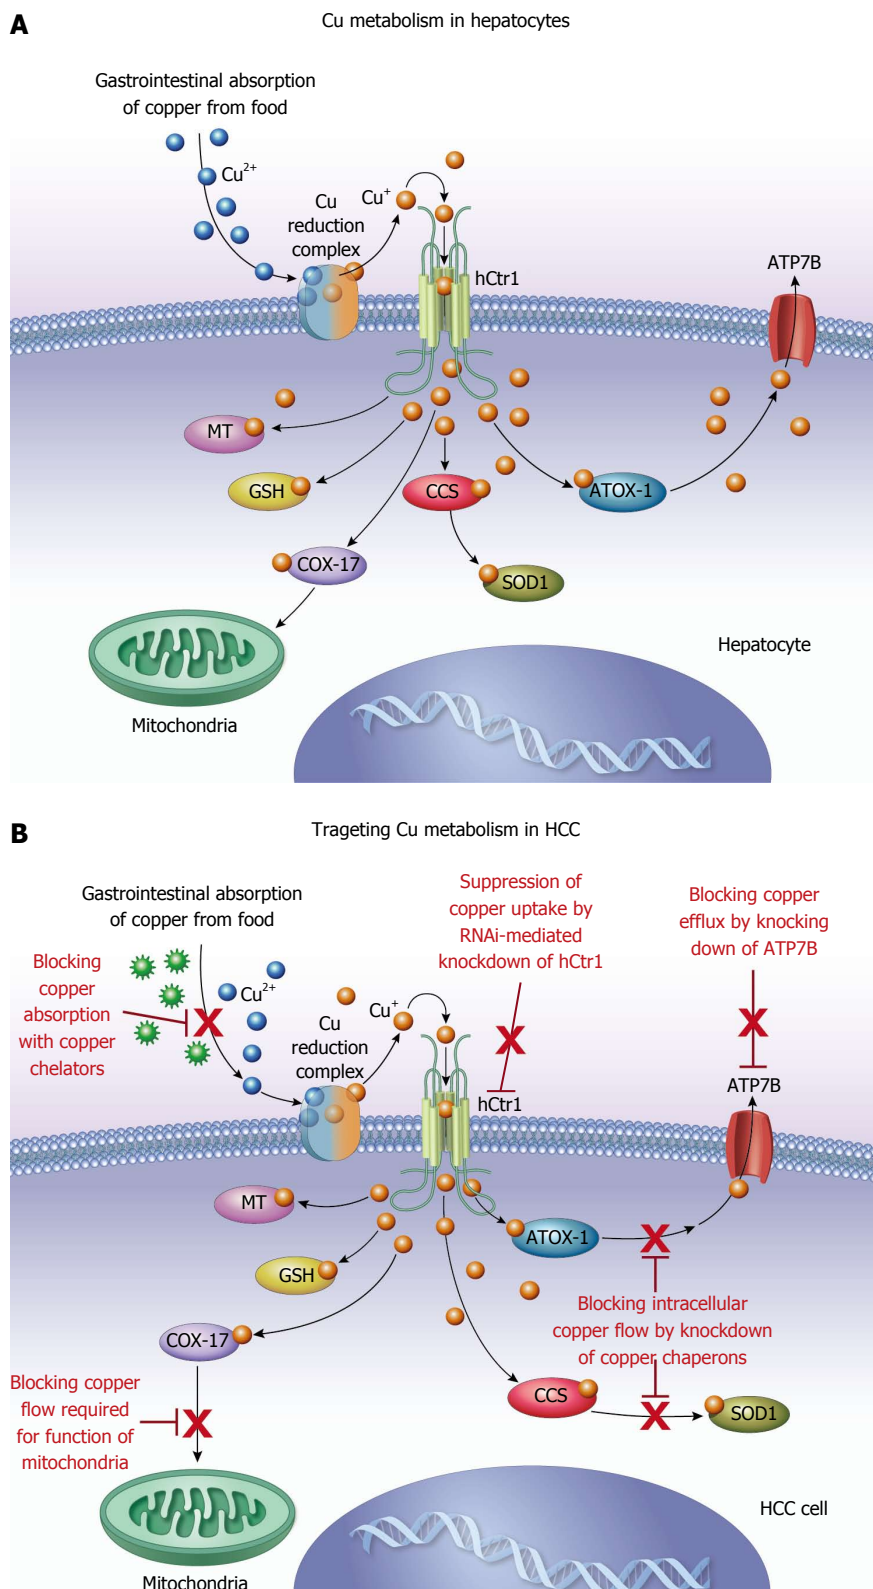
Perspective on targeting copper metabolism for the treatment of hepatocellular carcinoma. A: Copper metabolism in hepatocytes. Copper metabolism in hepatocytes is regulated by a network of copper transporters and chaperons. Following copper uptake mediated by the influx copper transporter, hCtr1, copper is transported intracellularly by copper chaperons and copper homeostasis is maintained by the outflow of copper mediated by the efflux copper transporter, ATP7B; B: Targeting copper metabolism for the treatment of hepatocellular carcinoma (HCC). Copper is required for cell proliferation and may play a role in the signaling transduction pathway regulating proliferation of HCC cells. Targeting copper metabolism with copper chelators has been tested for anti-copper therapy of HCC, with variable response. RNAi-mediated knockdown of hCtr1 and/or other copper chaperons is a potential new approach for targeted anti-copper gene therapy of HCC. Furthermore, ionic $^{64}\text{CuCl}_2$ or $^{67}\text{CuCl}_2$ have potential as new radiopharmaceuticals for systemic radionuclide therapy of HCC, based on increased ^{64}Cu uptake of HCC visualized on preclinical PET/CT images. hCtr1: Human copper transporter 1; ATOX-1: Antioxidant 1; Cox 17: Cytochrome c oxidase 17; CCS: Copper chaperone for superoxide dismutase; SOD1: Superoxide dismutase 1; GSH: Glutathione; MT: Metallothionein; ATP7A: Copper-transporting ATPase 1; ATP7B: Copper-transporting ATPase 2; PET/CT: Hybrid position emission tomography and computed tomography.
